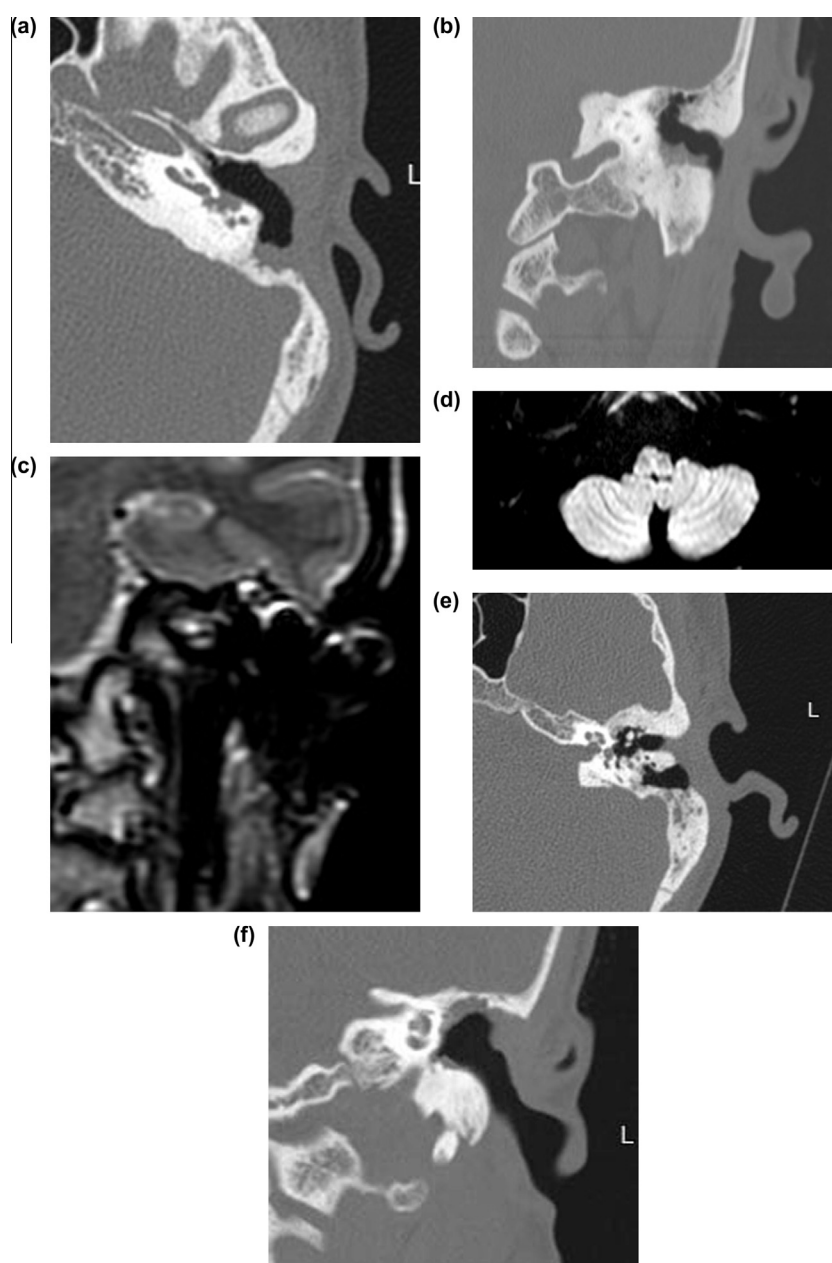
(a–f) A 45 years old patient underwent left sided mastoidectomy was referred 15 months later due to ear ache and discharge, axial (a) and coronal (b) CT scans showed irregular erosive soft tissue lesion in the operative bed, T2 coronal MRI (c) and DWI MRI (d) showed mild irregular mucosal thickening in the operative bed with no diffusion restriction likely representing infected granulation tissue, after conservative management follow up axial (e) and coronal (f) CT showed regression of the inflammatory process excluding the possibility of recurrent cholesteatoma.
